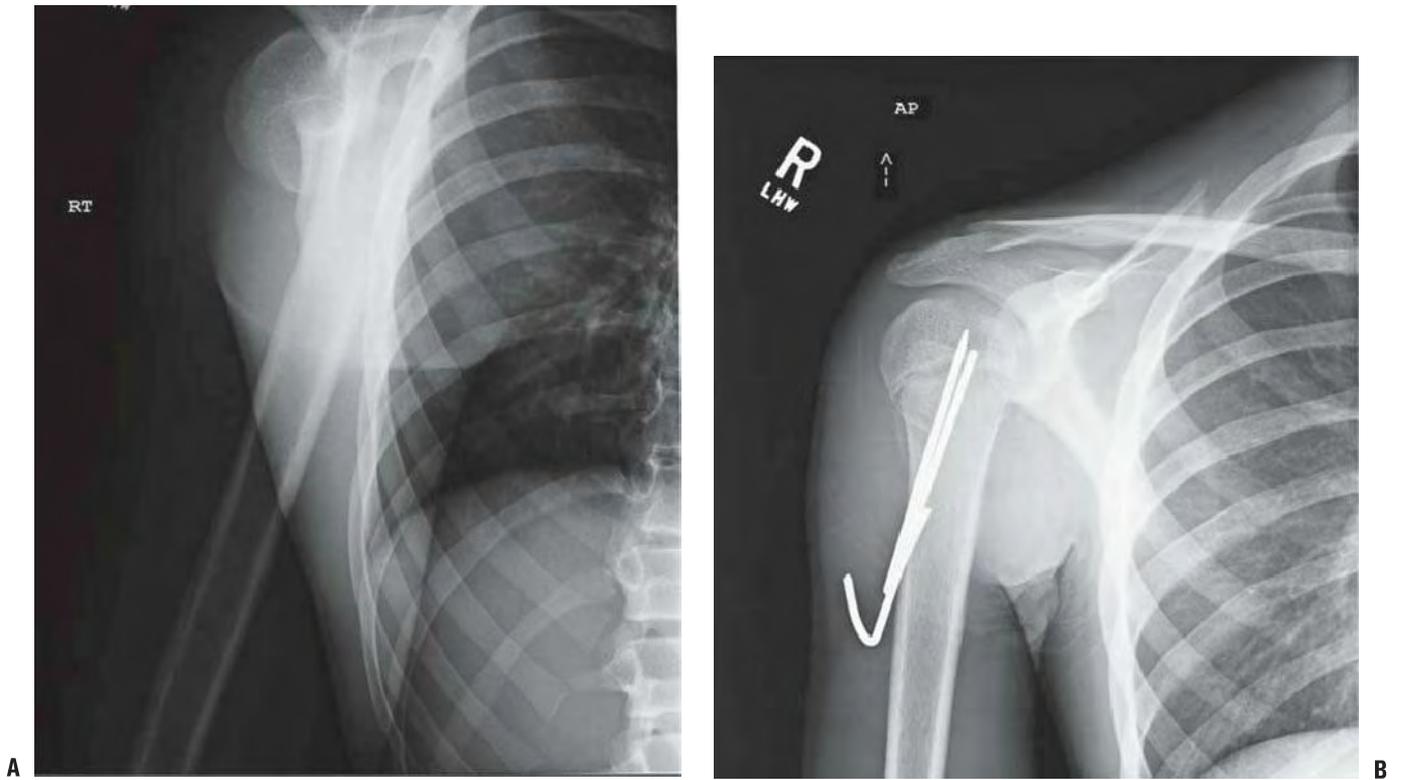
A, B: Radiographs of severely displaced fracture that was unstable after reduction and stabilized with distal to proximal pins, with pins bent outside skin.
